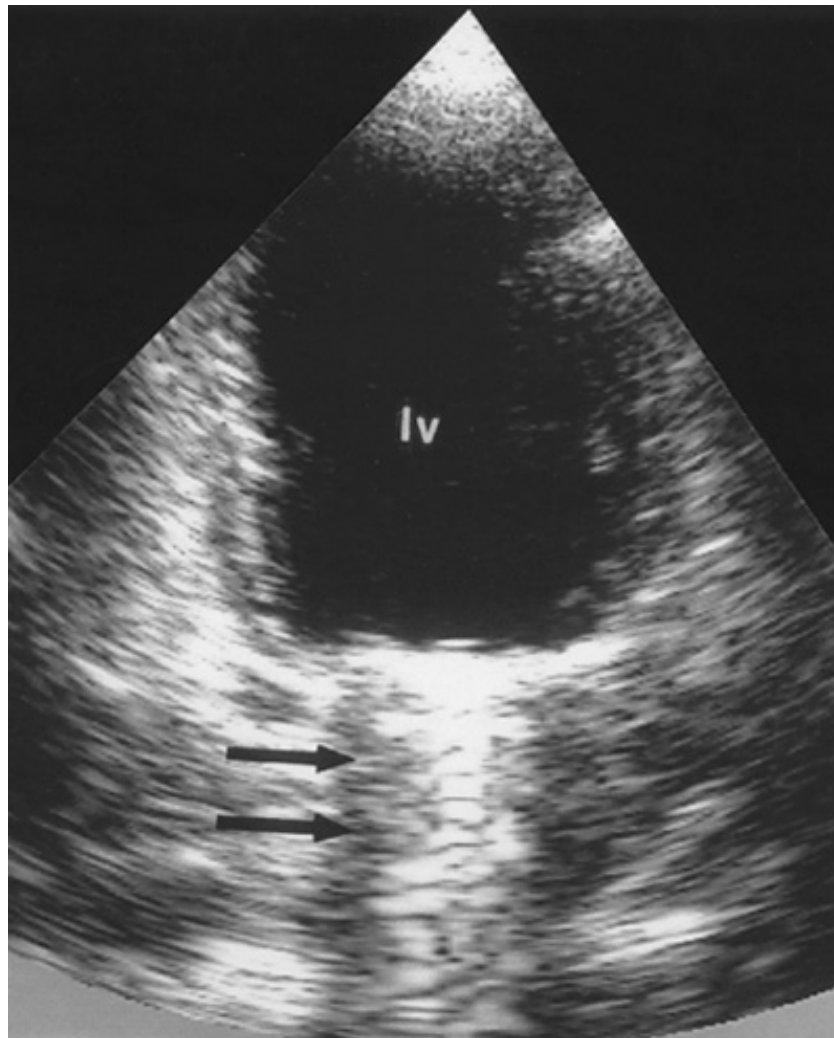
Apical two-chamber view of a mechanical prosthetic valve (mitral position) during systole. The left atrium is completely obscured by ultrasonic shadowing (*arrows*). LV = left ventricle.
